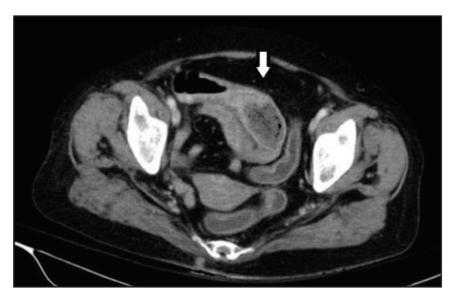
Axial view of CT abdomen showing a lesion having mottled appearance and air bubbles within in the lumen of the small bowel (white arrow).
